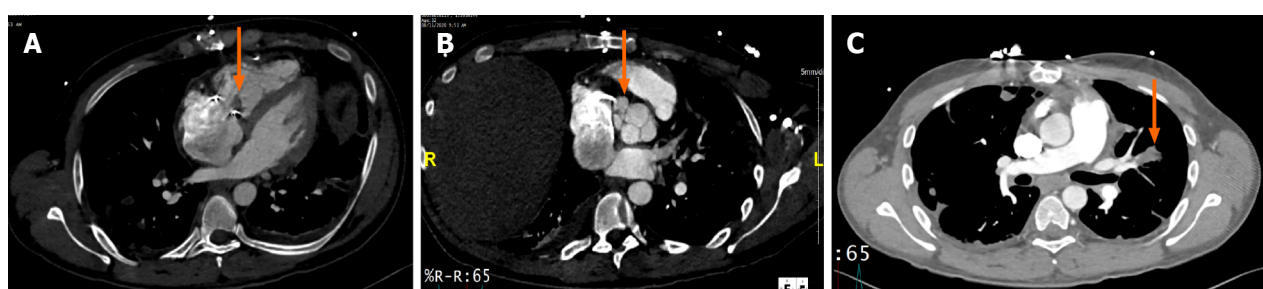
Cardiac computed tomography in a patient with tricuspid valve replacement endocarditis with peri-valvular extension. Thirty-two year-old male with a history of intravenous drug abuse status post bioprosthetic tricuspid valve replacement presenting with methicillin-sensitive *Staphylococcus Aureus* due to relapsed drug abuse. Cardiac computed tomography demonstrated thickening of the valve leaflets (A: Arrow) and a 2.7 cm × 1.9 cm × 1.4 cm lobulated pocket of free-flowing blood/contrast interposed between the tricuspid annulus and the aortic annulus consistent with abscess/fistula (B: Arrow). Prominent pulmonary septal embolism was also detected (C: Arrow).
